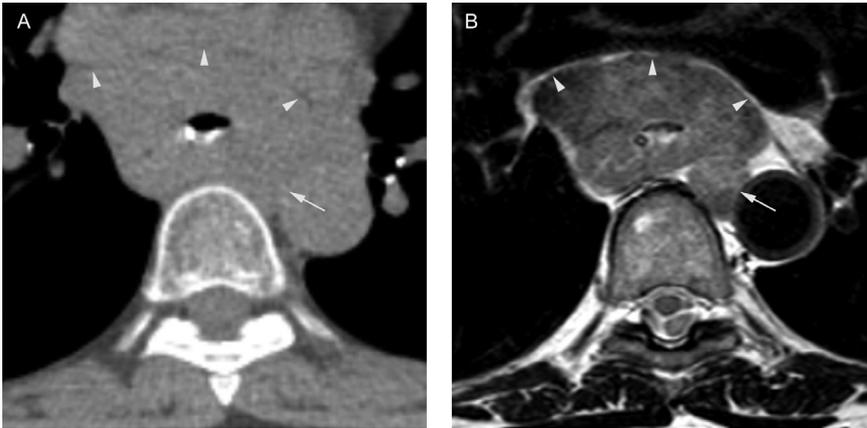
A) Standard axial non-contrast-enhanced CT image for radiotherapy purposes in a patient with a cT3N3M1 esophageal squamous cell carcinoma. Direct tumor contact with the aorta (*arrow*) and/or pericardium (*arrowheads*) may be suspected based on this image. B) An axial T2W 1.5-T MR image clearly reveals an enlarged peritumoral lymph node with suspected metastasis (*arrow*) adjacent to the aorta, rather than the primary tumor itself. Also, the delineation of the tumor at the pericardial site seems more clearly depicted (*arrowheads*).
